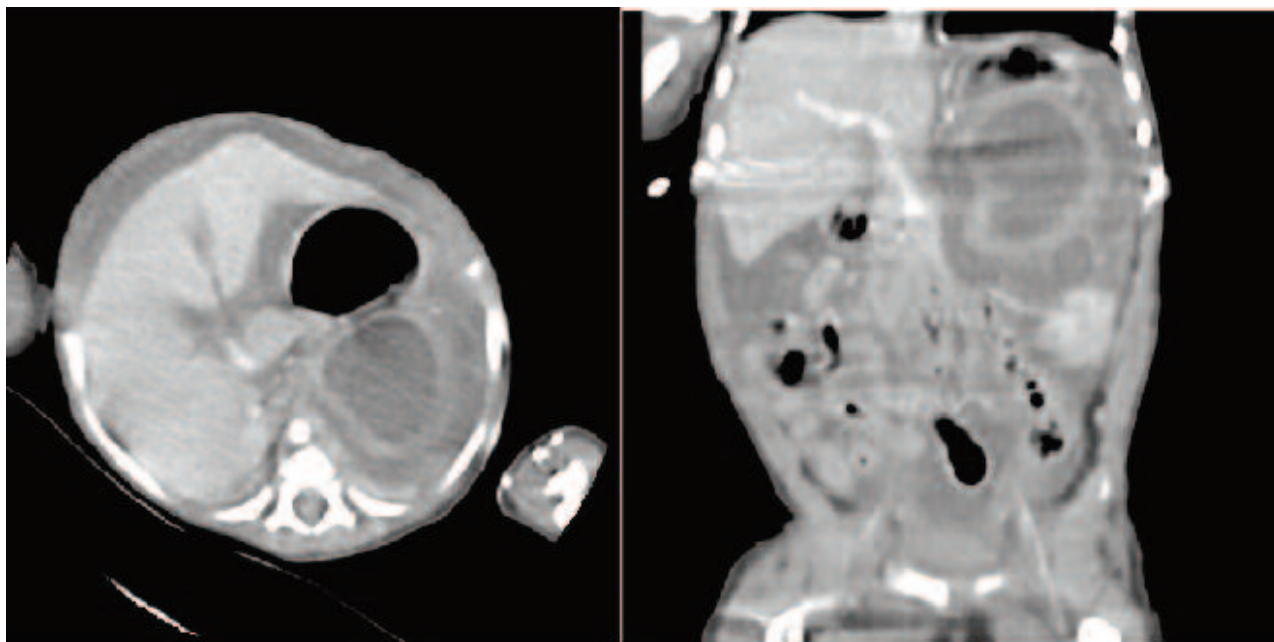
CT demonstrates an intraabdominal cyst on upper left quadrant.
